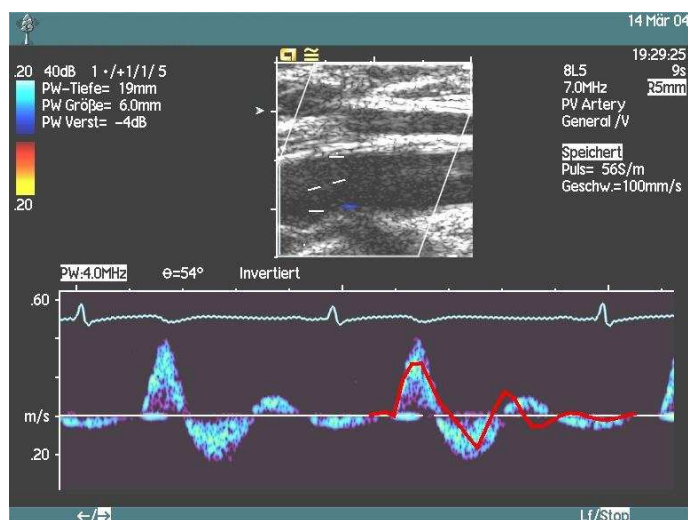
Comparison of computed flow velocity with ultrasound measurement in the femoral artery
